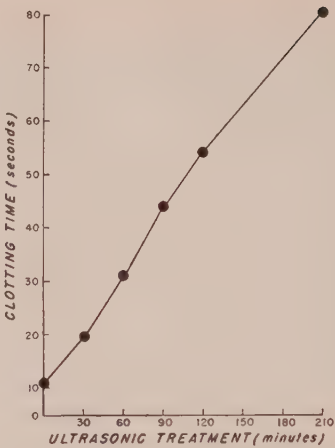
Loss in clotting potency of human brain thromboplastin due to ultrasonic treatment.
